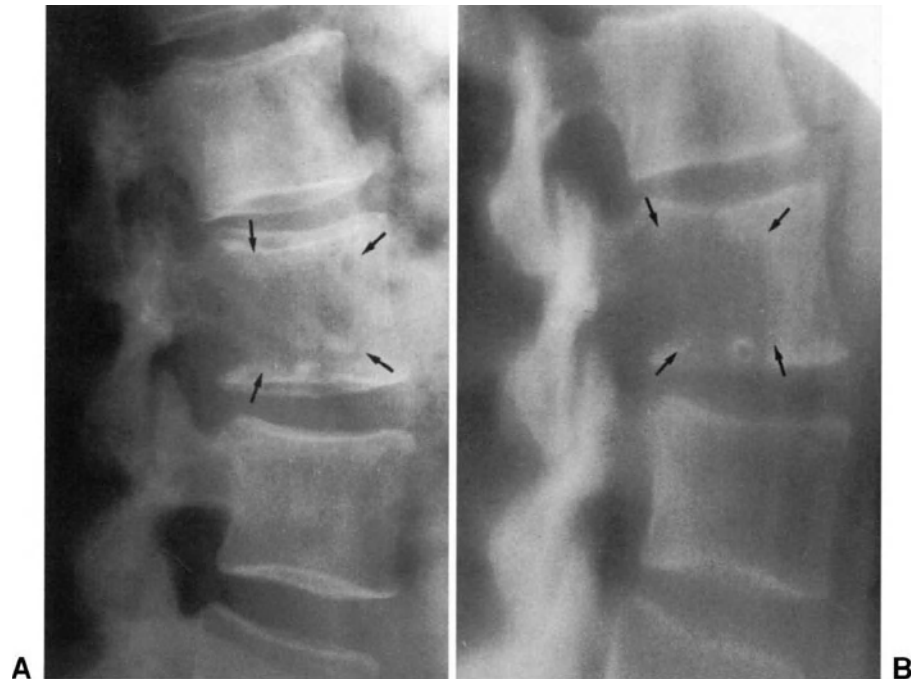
Metastasis of breast carcinoma in the L₃ vertebra. The radiograph (A) shows an osteolytic lesion of the vertebral body (arrows), presenting a defect in the posterior cortical bone. The lesion is clearly visible on the tomogram (B).
